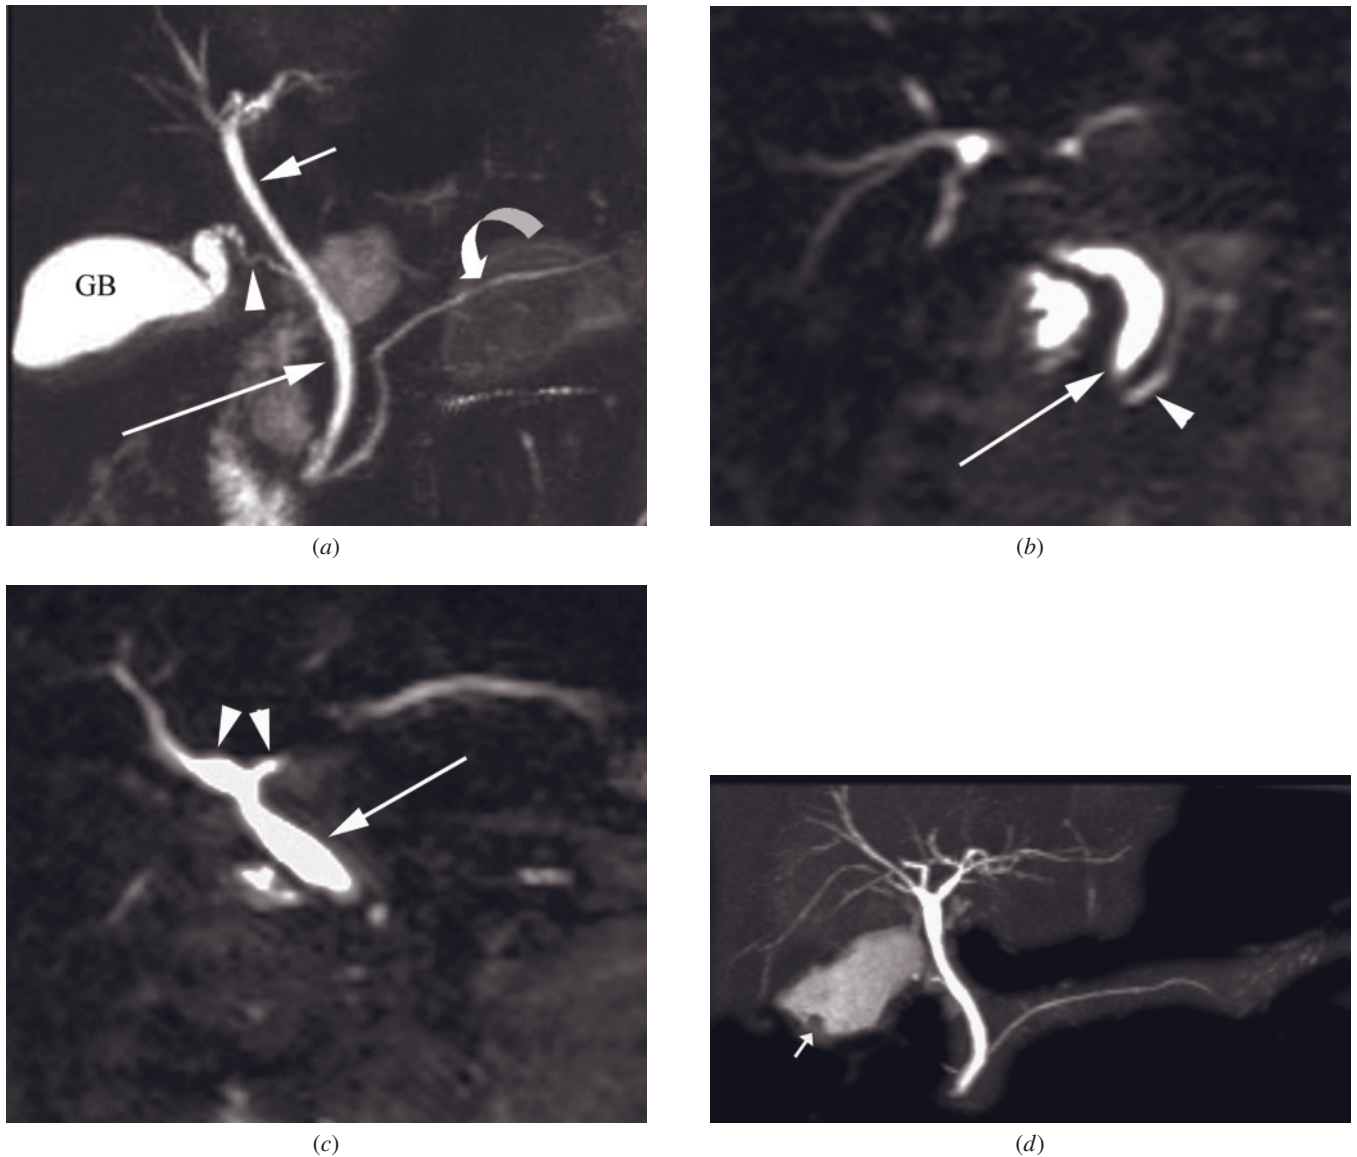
Normal biliary system, MRCP. Thick-slab T2-weighted fat-suppressed single-shot echo-train spin-echo image (*a*) showing a good overview of the normal intra- and extrahepatic biliary system depicting the gallbladder (GB, *a*), the common bile duct (long arrow, *a*), the common hepatic duct (short arrow, *a*), the cystic duct (arrowhead, *a*), and the pancreatic duct (curved arrow, *a*). Thin-slab T2-weighted fat-suppressed single-shot echo-train spin-echo images (*b*, *c*) in a different patient demonstrate more detail and allow exact evaluation of the lumen and walls of the preampullary section of the common bile duct (long arrow, *b*), the pancreatic duct (short arrow, *b*), the common hepatic duct (long arrow, *c*), and the confluence of the right and left hepatic ducts (arrowheads, *c*). Navigator pulse triggered 30-MRCP in a third patient shows excellent depiction of biliary and pancreatic ducts. A gallstone is present in the gallbladder (arrow, *d*).
